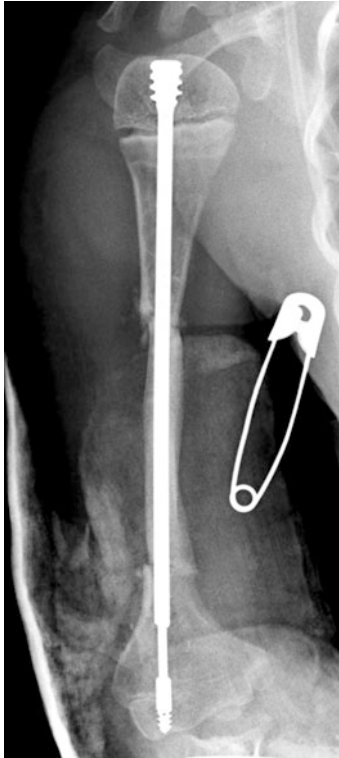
Immediate postoperative anteroposterior radiograph of the humerus with the Fassier-Duval rod in situ
